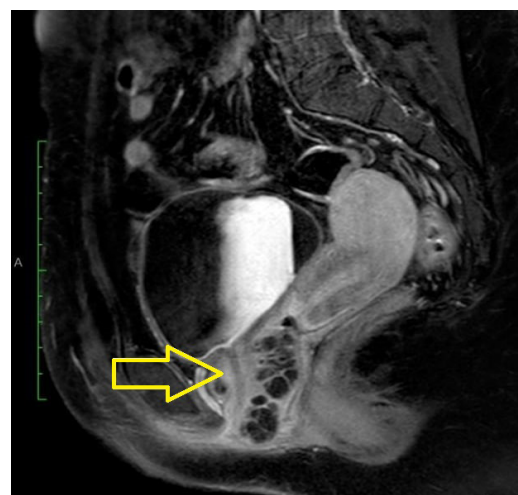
T1-weighted post contrast sagittal – magnetic resonance imaging scan showing the diverticulum displacing the bladder base upwards minimally and exhibiting mass effect onto the vagina causing slit like appearance of the vaginal lumen.
